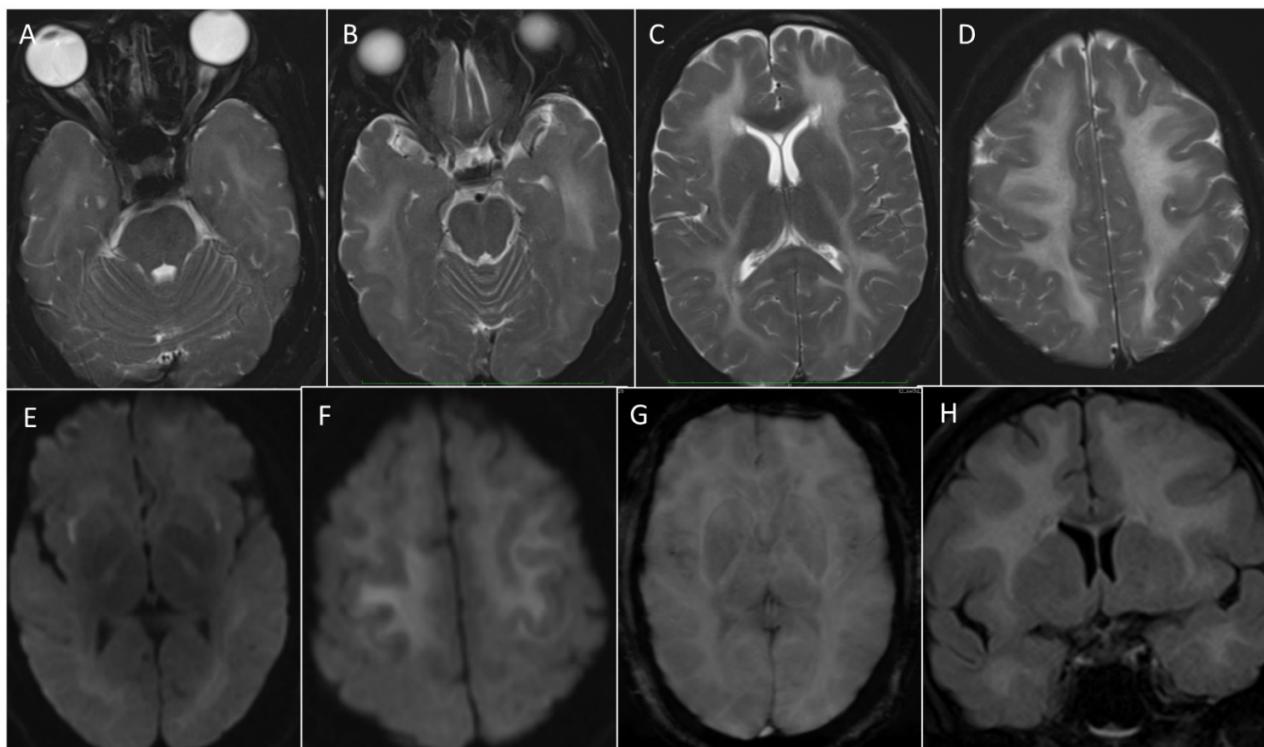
Leukoencephalopathy. 41-year-old male with history of COVID 19 infection presented with seizures progressing to altered sensorium. MRI of the brain Axial T2 (A - D), Axial DWI (E & F), Axial GRE (G) and Coronal T1(H) revealed confluent white matter hyperintensity involving bilateral cerebral hemispheres with corresponding areas of diffusion hyperintensity. No hemorrhage or abnormal mineralization noted.
